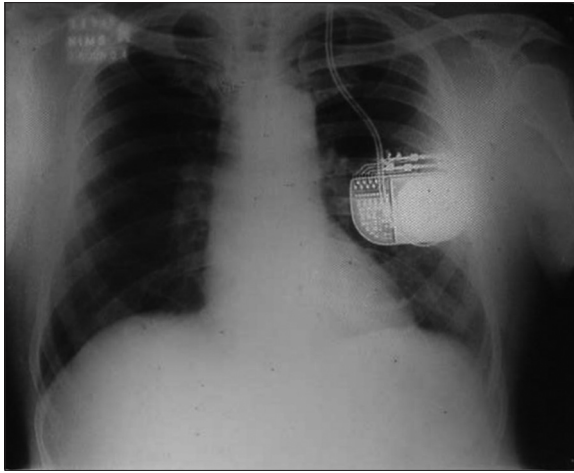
X-ray showing neurostimulator implanted in fifth intercostal space (the placement of electrode was done in subthalamic nucleus)
